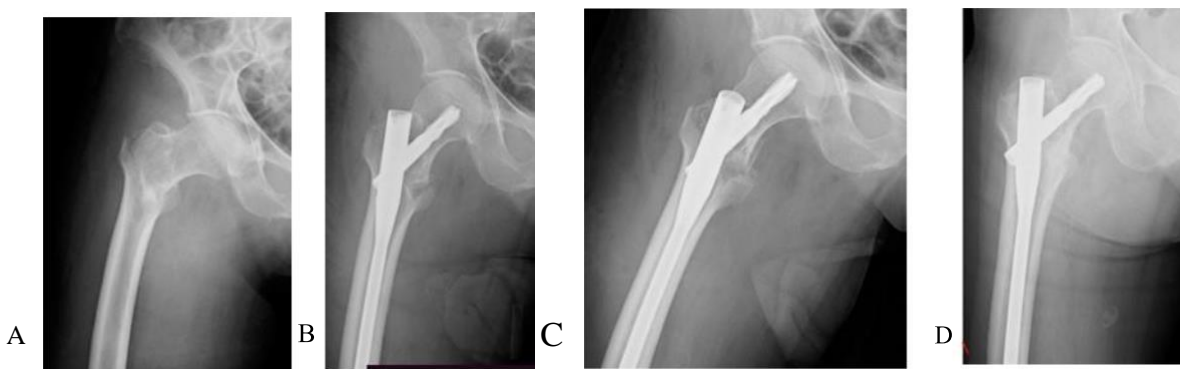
A) 68-year old female patient with a right unstable intertrochanteric fracture B, C) immediate post-operative AP/Lateral x-rays show good reduction. D) At 8-month follow-up
